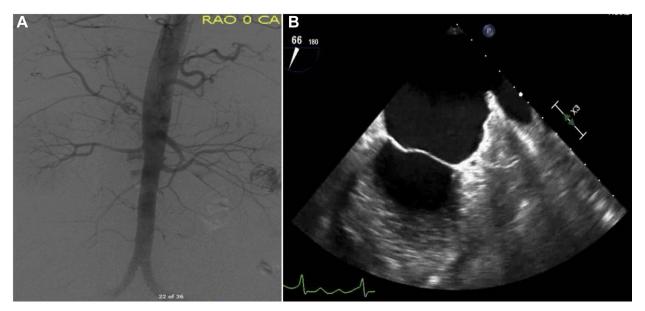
Postprocedure imaging. A: An aortogram with peripheral runoff was performed to assess for emboli to the kidneys, spleen, and mesenteric system. None was detected. B: Transesophageal echocardiogram 45 days postimplant showed normal device location and compression. No device-associated thrombus.
